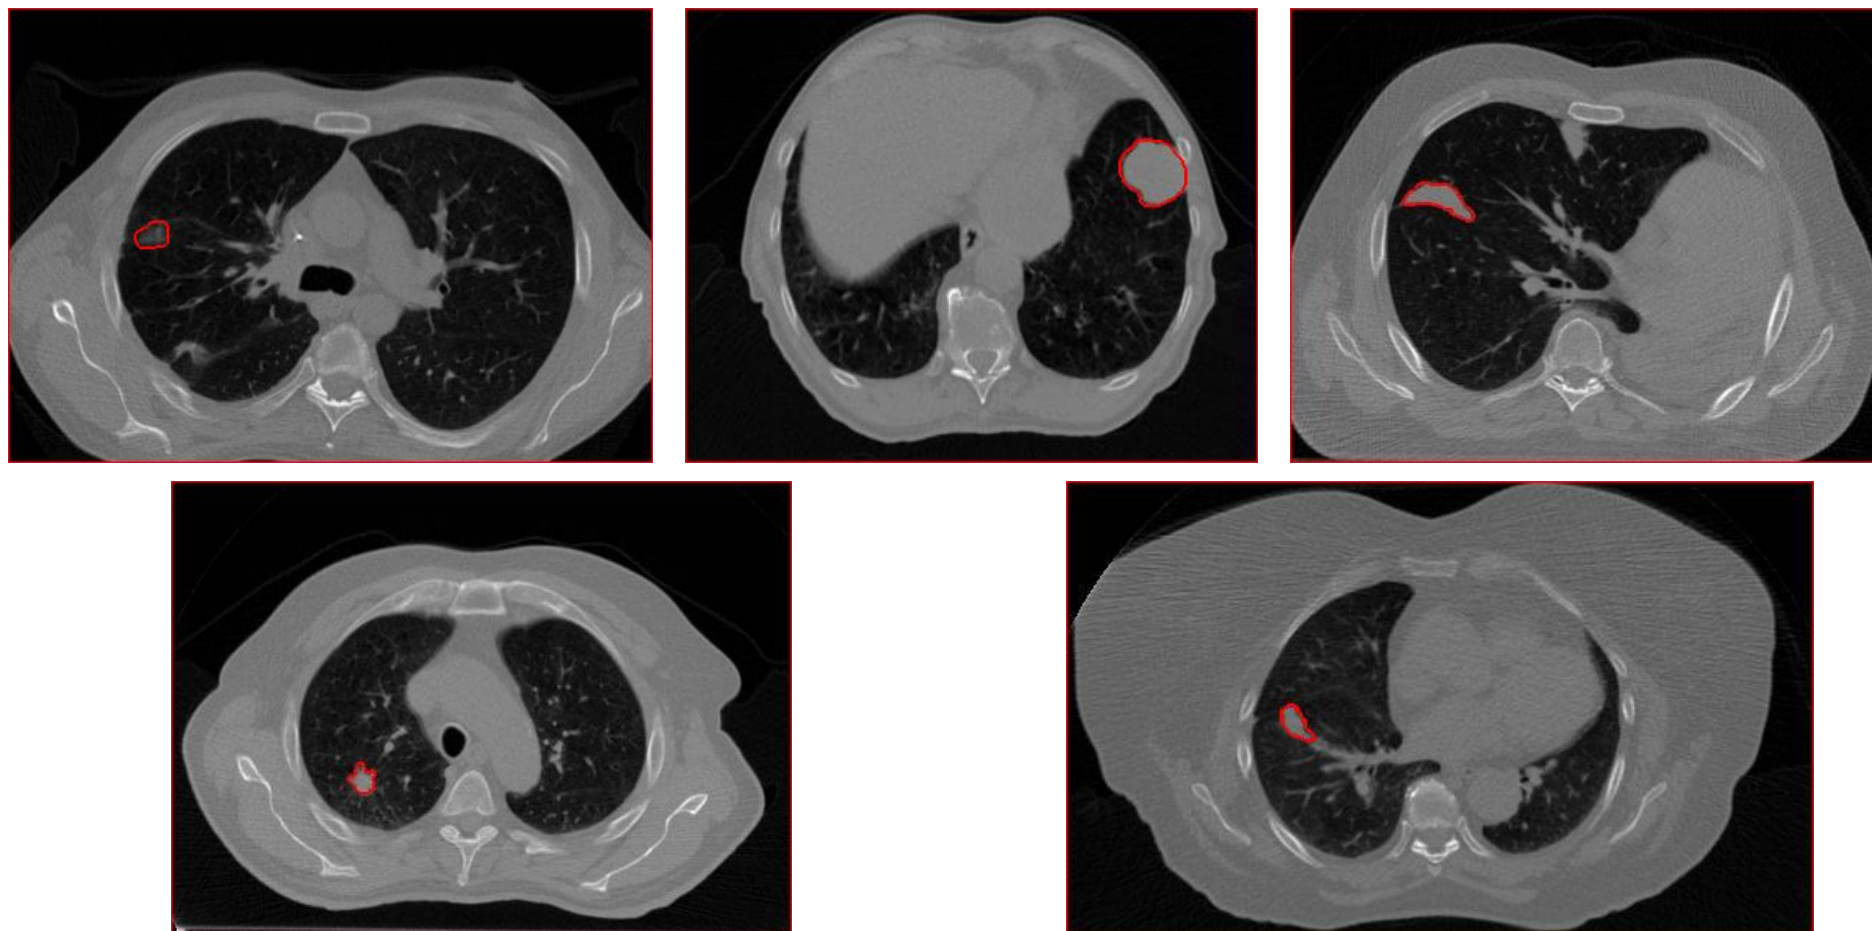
Visualization of the 4D CT lung images studied from five patients treated for locally advanced non-small cell lung cancer (NSCLC). For each patient the tumor is located by a red contour.
